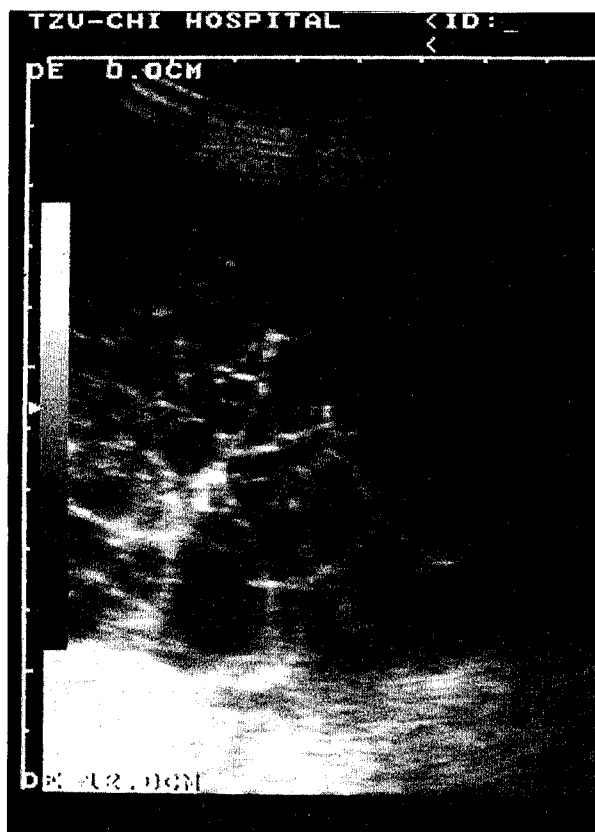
Chest sonography showing the right pleural effusion becoming septated on the second admission.
